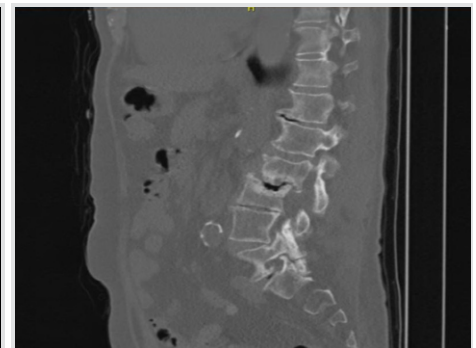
A positron-emission tomography-computed tomography image of the presented case, which shows no clear signs of infection but severe degeneration of the lumbar spine especially at level L2-L3.
